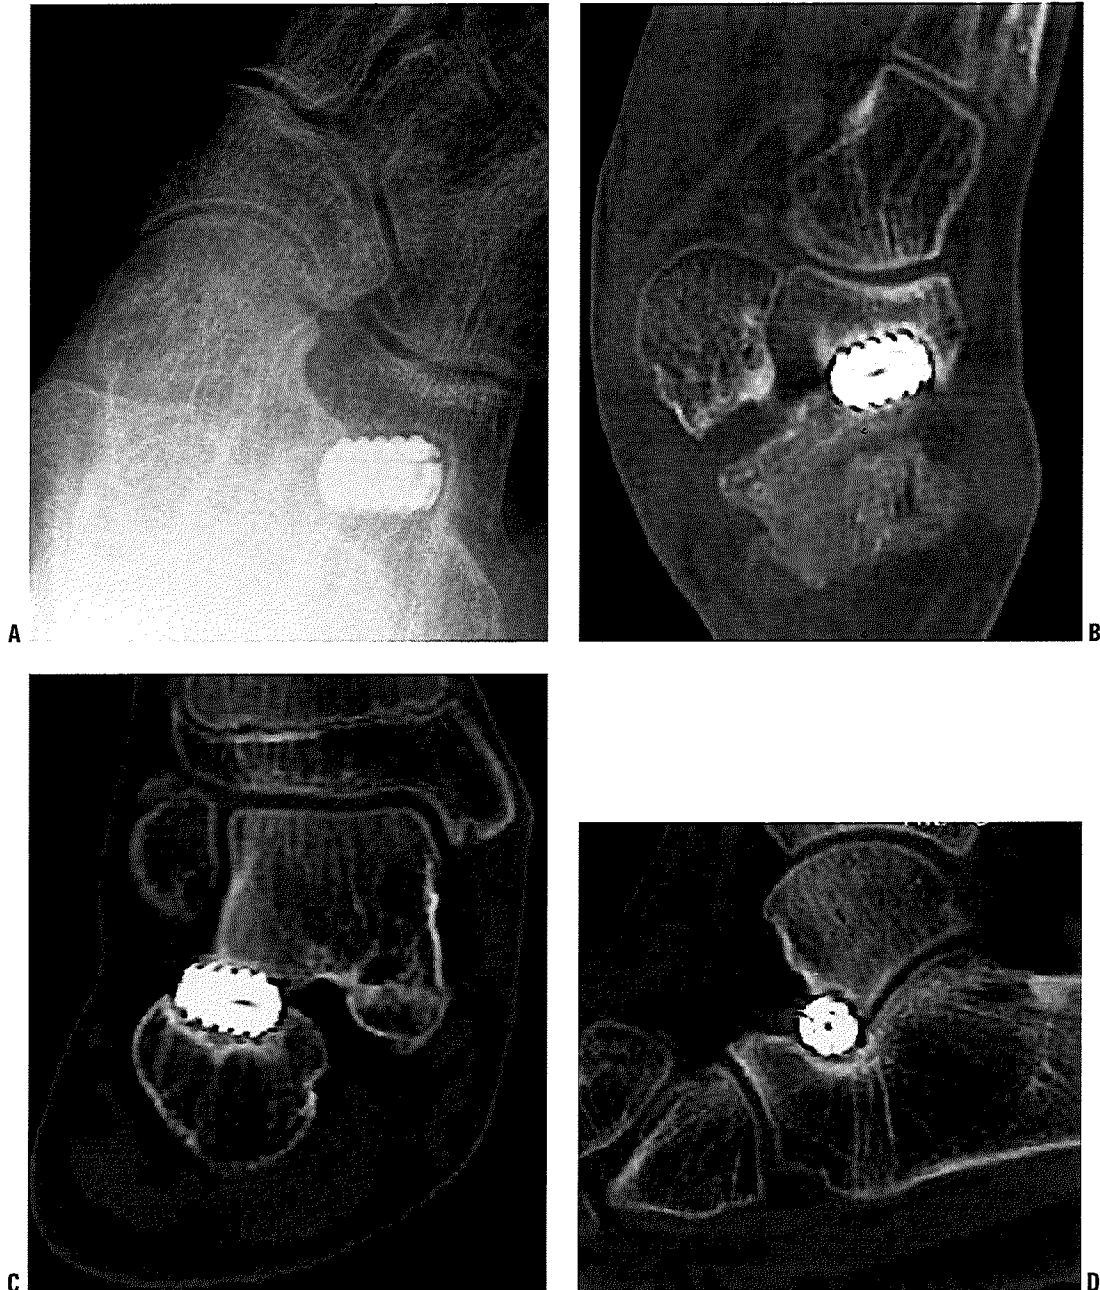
X-ray and CT scan images showing bone resorption around an MBA implant. A: AP x-ray. B: Transverse plane CT scan image. C: Coronal plane CT scan image. D: Sagittal plane CT scan image. (From Mosca VS. Flexible flatfoot and skewfoot. In: McCarthy J and Drennan JC, eds. *The Child's Foot and Ankle*. 2nd ed. Lippincott Williams & Wilkins, 2009:147, with permission.)
